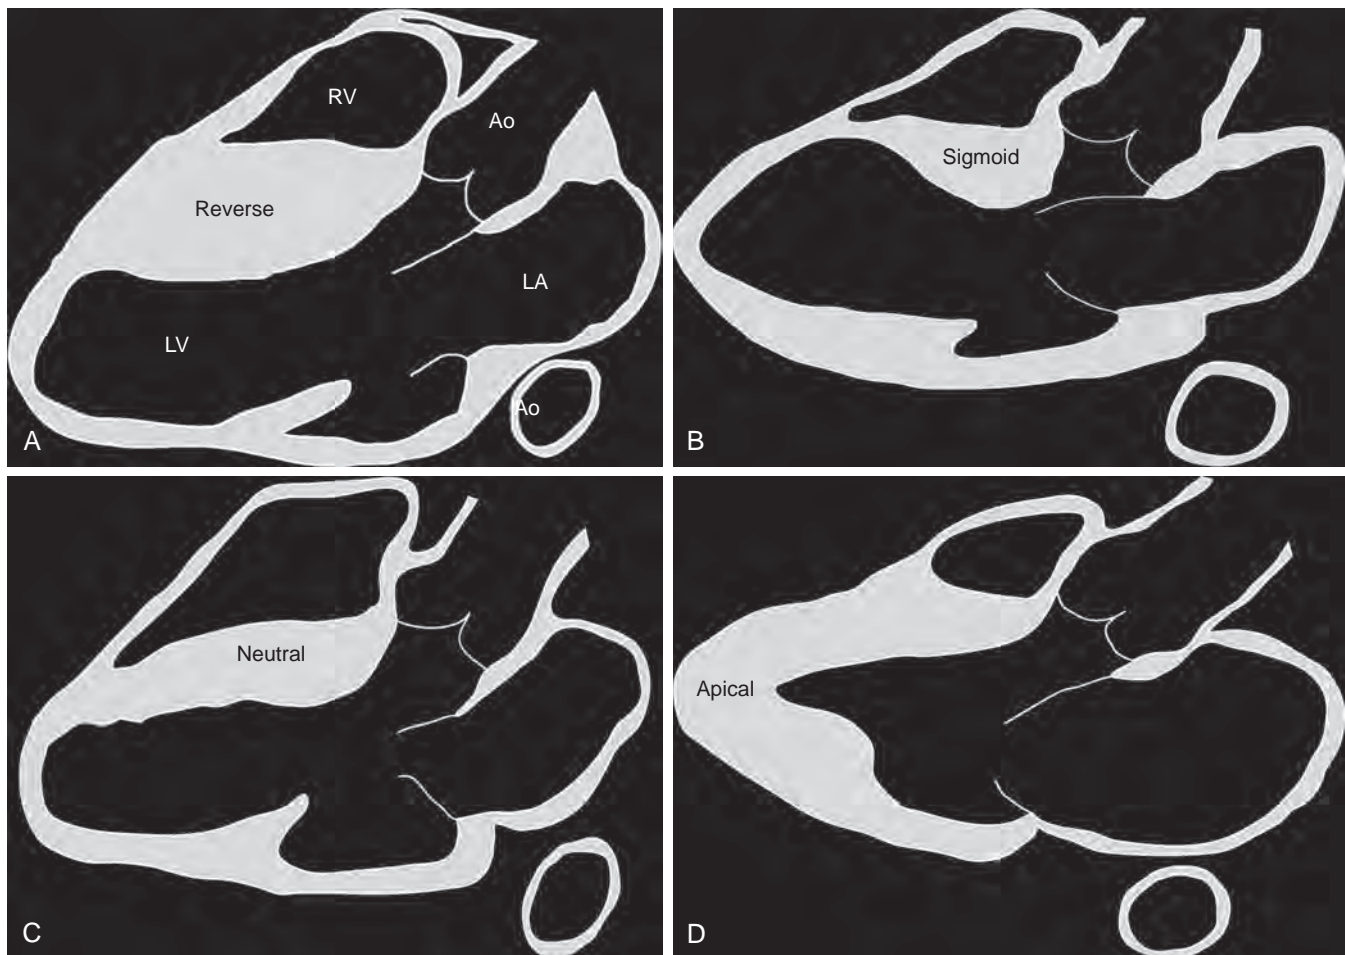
Phenotypic variants seen on echocardiography in patients with hypertrophic cardiomyopathy. (A) The reverse curvature type shows a markedly thickened septum with the endocardial curve convex instead of the expected concave appearance. (B) The sigmoid curvature type shows a discrete region of asymmetric septal thickening near the outflow tract. (C) The neutral septum type demonstrates a uniformly thickened septum with the expected concave appearance of the septum. (D) The apical variant demonstrates asymmetric hypertrophy of the apical segments. Ao, Aorta; LA, left atrium; LV, left ventricle; RV, right ventricle. (Adapted from Syed IS, Ommen SR, Breen JF, Tajik AJ. Hypertrophic cardiomyopathy: identification of morphological subtypes by echocardiography and cardiac magnetic resonance imaging. *JACC Cardiovasc Imaging*. 2008;1:377–379.)
